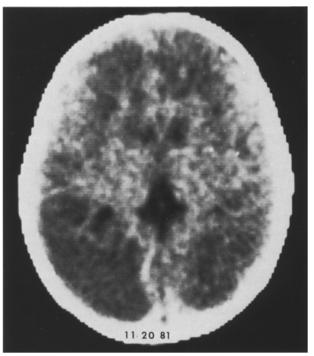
Chronic encephalopathy (encephalomalacia). 2-month-old infant: seizure and loss of consciousness following injury. There were multiple cutaneous injuries and retinal hemorrhages with skull and rib fractures. Initial CT examination (10-17-81) demonstrated diffuse cerebral edema and bilateral posterior superficial cerebral contusion-hemorrhage. Unenhanced CT (11-20-81): 1 month later bilateral extensive but predominantly posterior reduction in attenuation consistent with encephalomalacia. The child had severe mental and motor retardation
